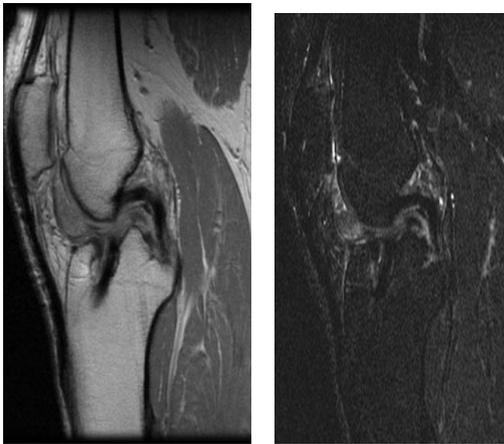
(a) Sagittal PD (b) Sagittal STIR MR images show intact ACL graft, cyclops
